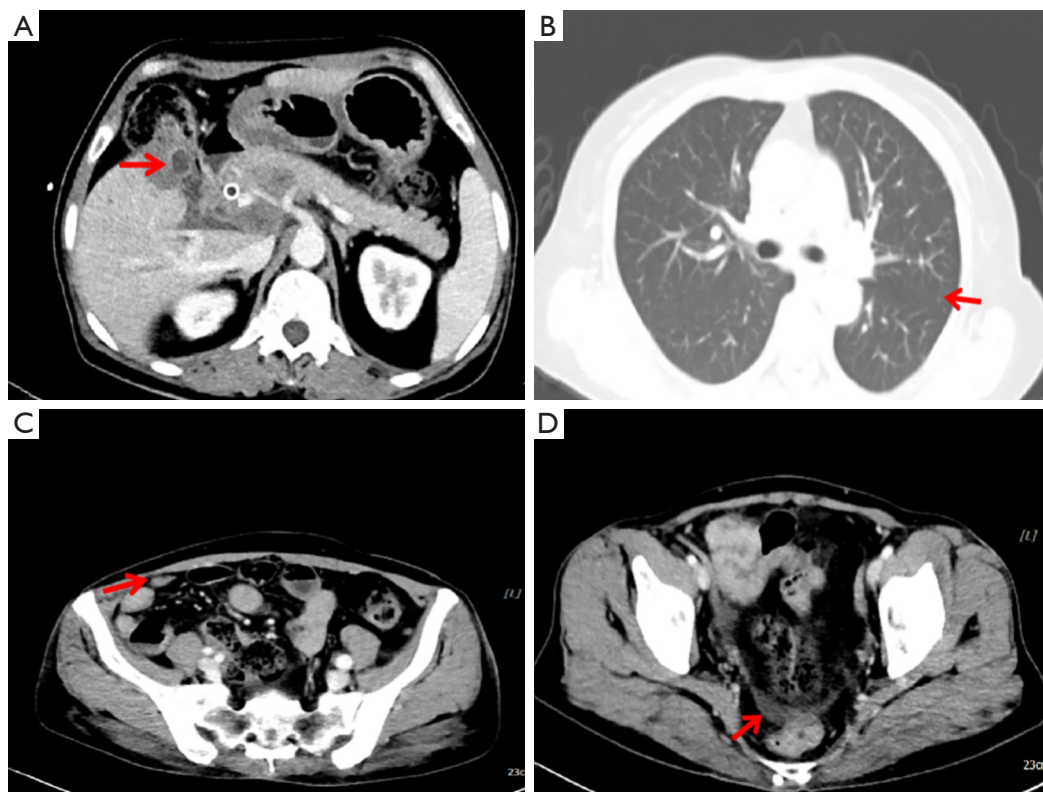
Major lesions after six cycles of chemotherapy. Significant changes indicated by red arrows. (A) The abdominal enhanced CT image; the gallbladder and the surrounding intrahepatic metastasis basically stable, reduced bile duct expansion; (B) the chest-enhanced CT image: double lung multiple metastases significantly reduced, close to all but disappear; (C) the pelvis enhanced CT image; Iliac fossa metastasis nodules are smaller and be insuflated and pushed to the abdominal wall; (D) the pelvic enhanced CT; the pelvic effusion decreased significantly. CT, computed tomography.
